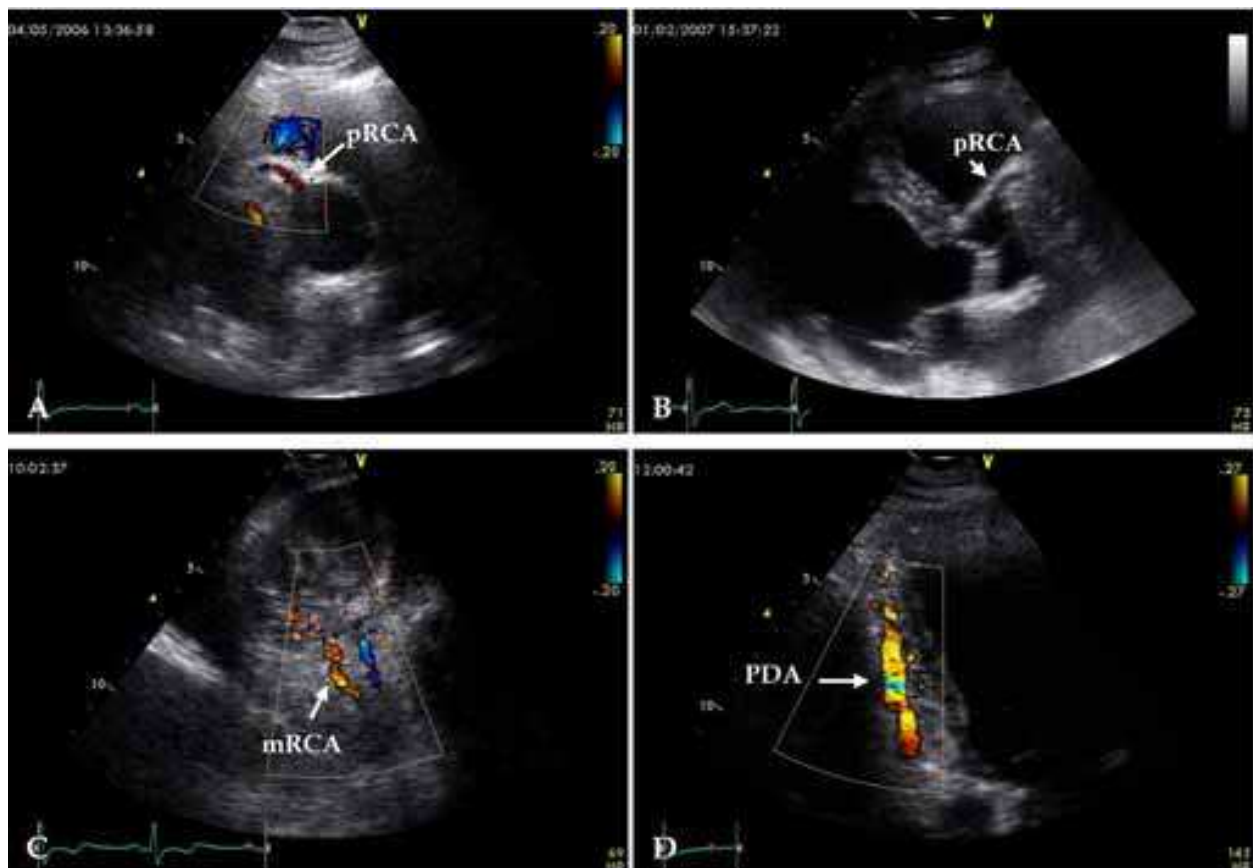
Color Doppler images of the RCA. Nyquist limit is 17-20 cm/s. A – proximal RCA (pRCA); the left parasternal position, a modified parasternal short-axis view of great vessels; B – pRCA; the left parasternal position, a modified parasternal long-axis view. C – mid RCA (mRCA); a modified apical two-chamber position with cranial angulation of the transducer; D – the PDA as distal RCA, the apical long-axis position, a modified two-chamber view.
